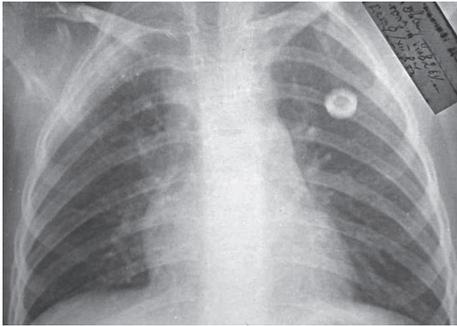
Radiography after surgical treatment (lobectomy of the upper lobe of the right lung with a cyst) of the same child
